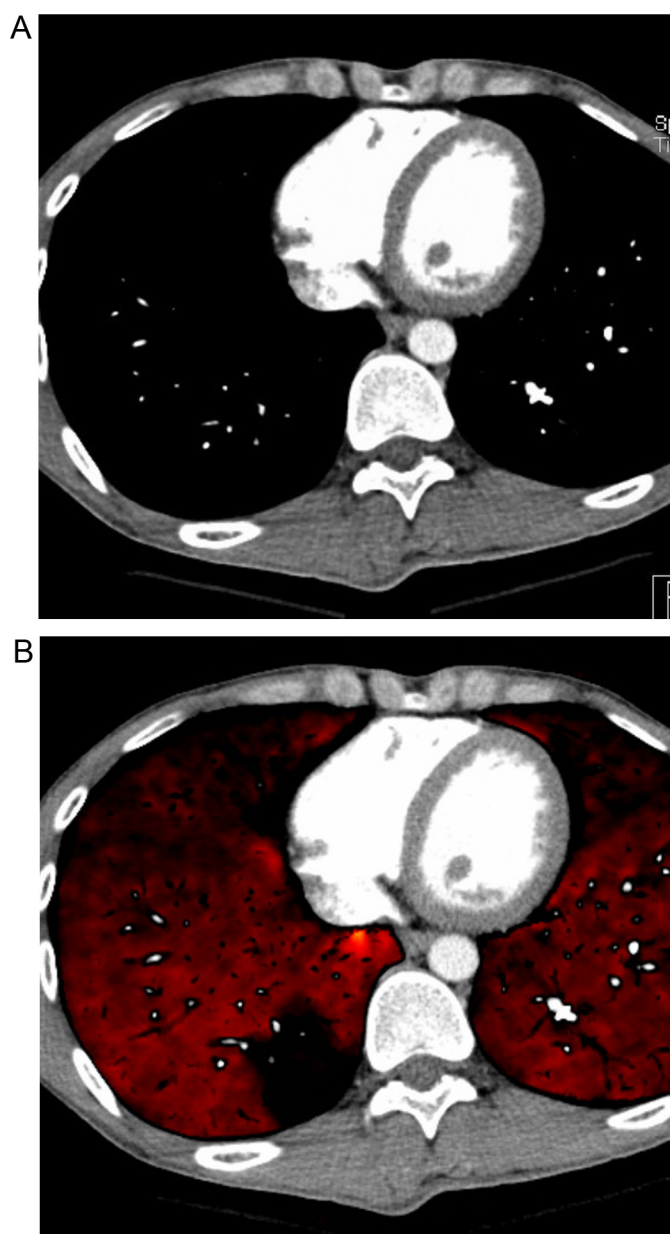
CT pulmonary angiography (CTPA) and CTPA combined with color-coded lung perfused blood volume (LPBV) images in a patient suspected of having acute pulmonary embolism. In the peripheral pulmonary segments, the intrapulmonary clot is difficult to distinguish from the neighboring segmental or subsegmental branches using a CTPA (A). A trapezoidal-shaped iodine perfusion defect attaching with dorsal pleura suggests the presence of intrapulmonary clot in a peripheral pulmonary segment (B).
